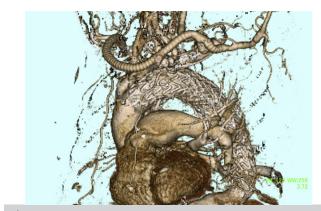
No endoleak was observed on postoperative contrast-enhanced computed tomography.
